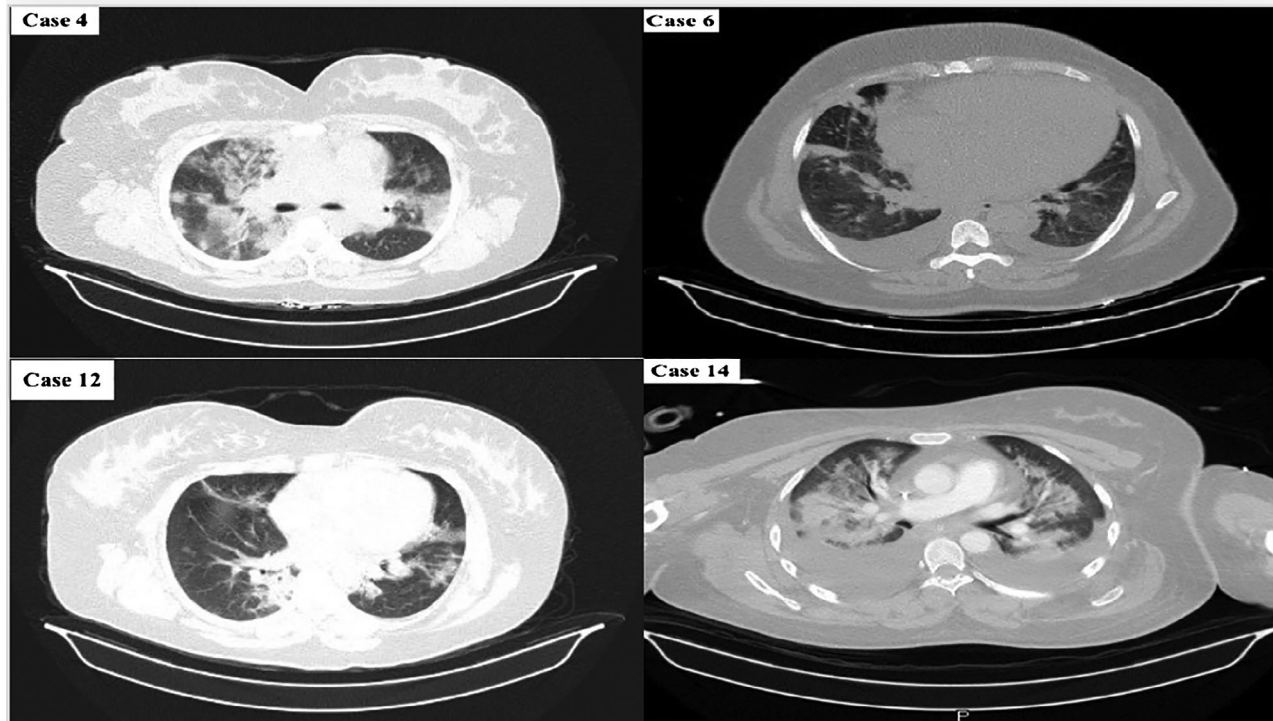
Pulmonary CT scan images of the patients who were admitted to the intensive care unit after cesarean section. Case 4. Ground-glass opacity, patch like shadows Case 6. Ground-glass opacity, patch like shadows, atelectasis, fiber shadows, pleural effusion. Case 12. Ground-glass opacity, patch like shadows. Case 14. Ground glass opacity, patch like shadows, fiber shadows, pleural effusion, atelectasis.
